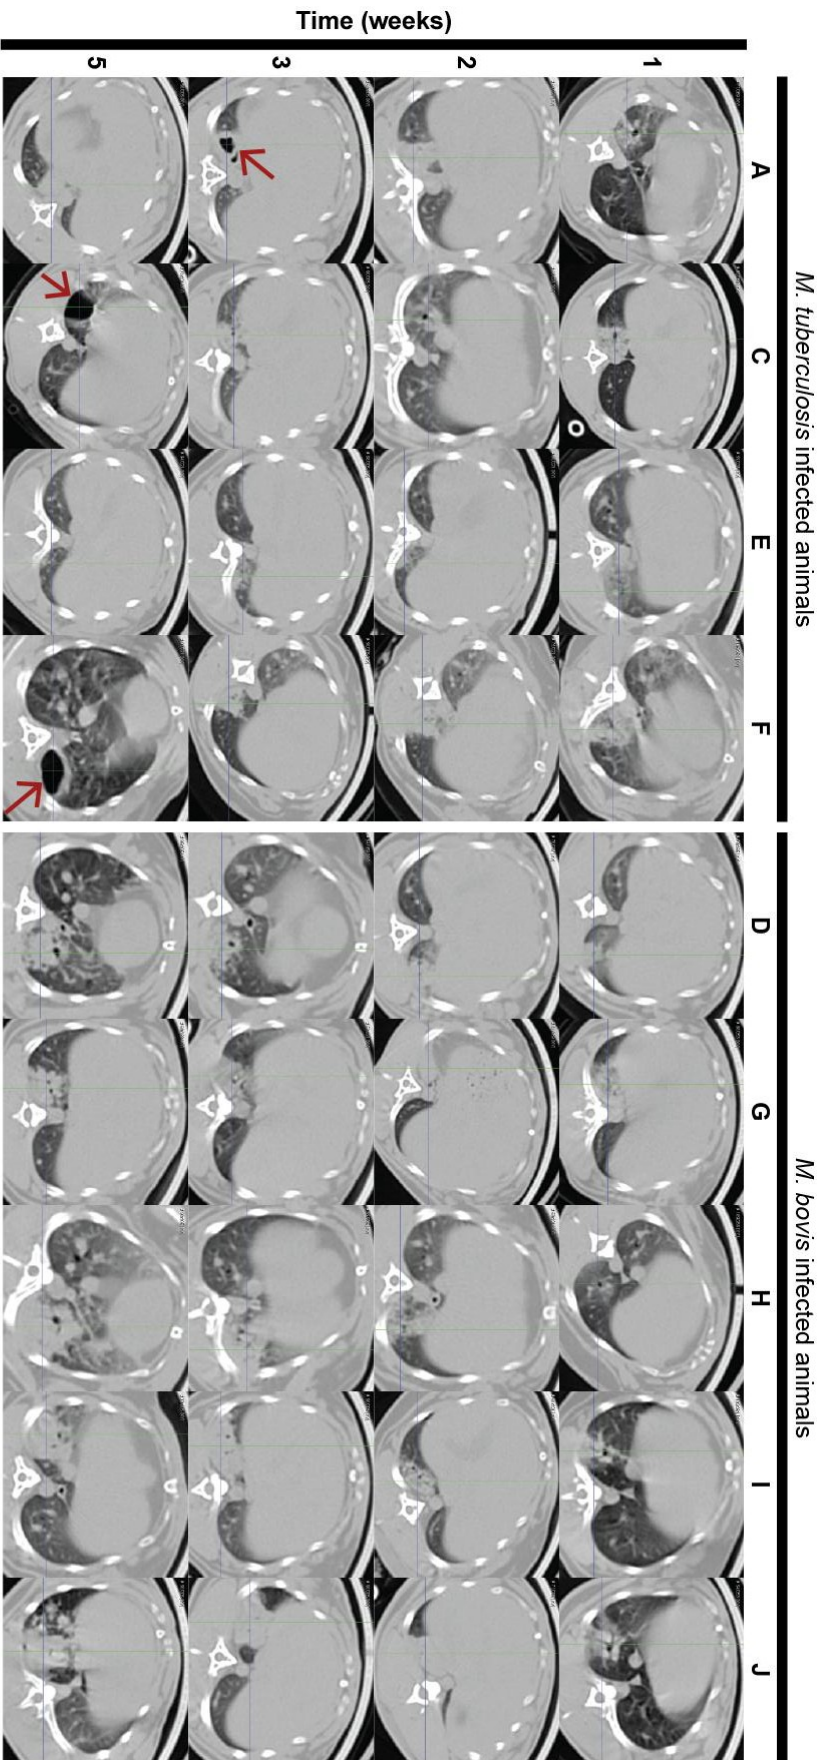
In vivo* imaging showed that *M. tuberculosis* infection resulted in more rapid cavity formation than *M. bovis* infection, despite lower amounts of inflammatory change: Transverse CT sections that demonstrating lesion progression in both infections. Cavitation events are marked by red arrows. Progressive extensive consolidation follows infection with *M. bovis* but not with *M. tuberculosis*.
